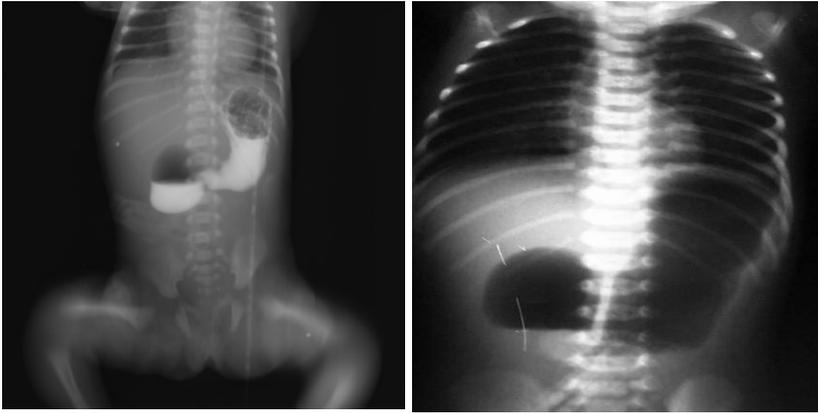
Pyloric atresia direct radiograph
